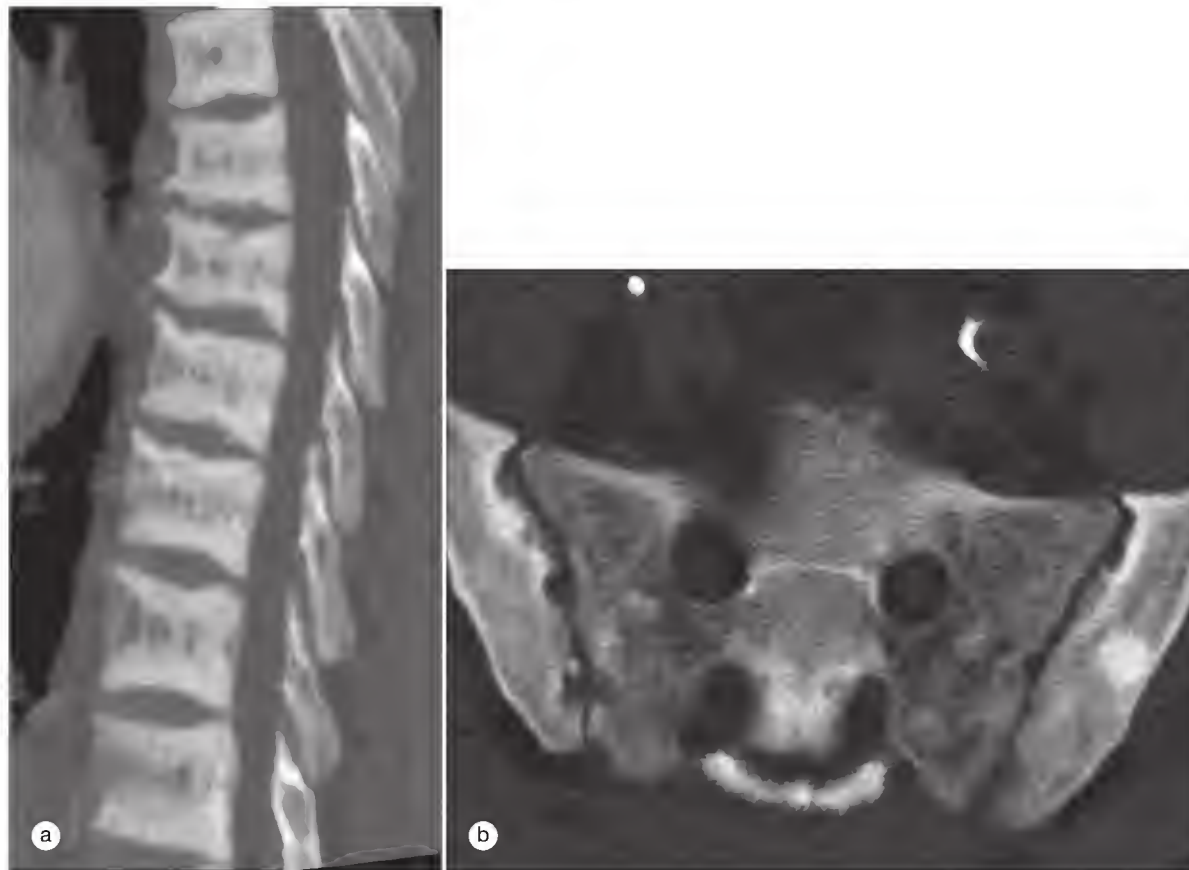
(a) "Rugger jersey" appearance of the spine clearly depicted on sagittal multiplanar reconstruction computed tomographic (CT) image. (b) Associated axial CT image demonstrating prominent sacroiliac joint erosions, mixed sclerosis, and loss of bone density. Findings are in keeping with the patient's history of renal osteodystrophy and hyperparathyroidism.
